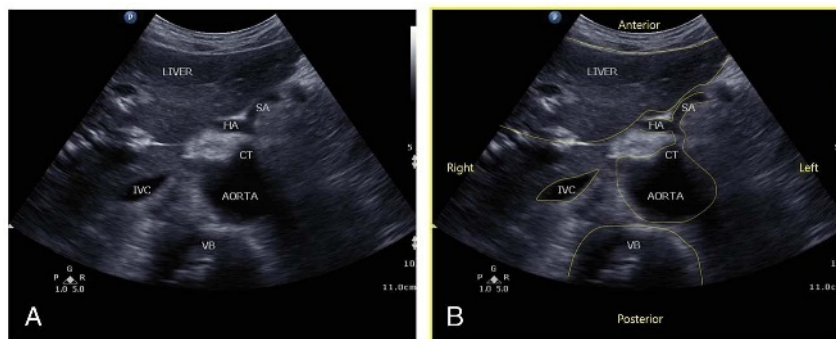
Transverse sonographic image of vertebral body and aorta below the xiphisternum showing the possible location of the celiac plexus. IVC indicates inferior vena cava; CT, celiac trunk; HA, hepatic artery; SA, splenic artery; VB, vertebral body.
